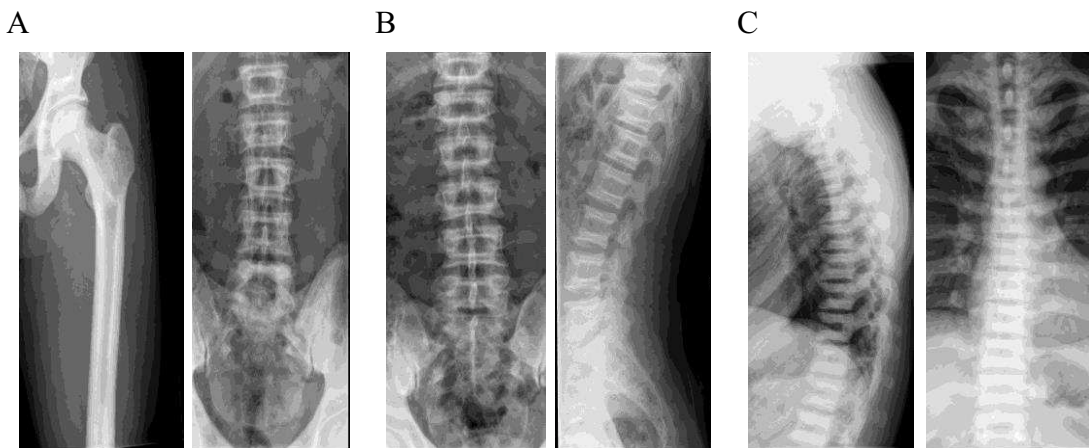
X-ray images of the patients of Family 2 showing the classical sandwich vertebrae and bone-in-bone appearance. (A), (B) and (C) show pictures of the three distinct patients, respectively.
